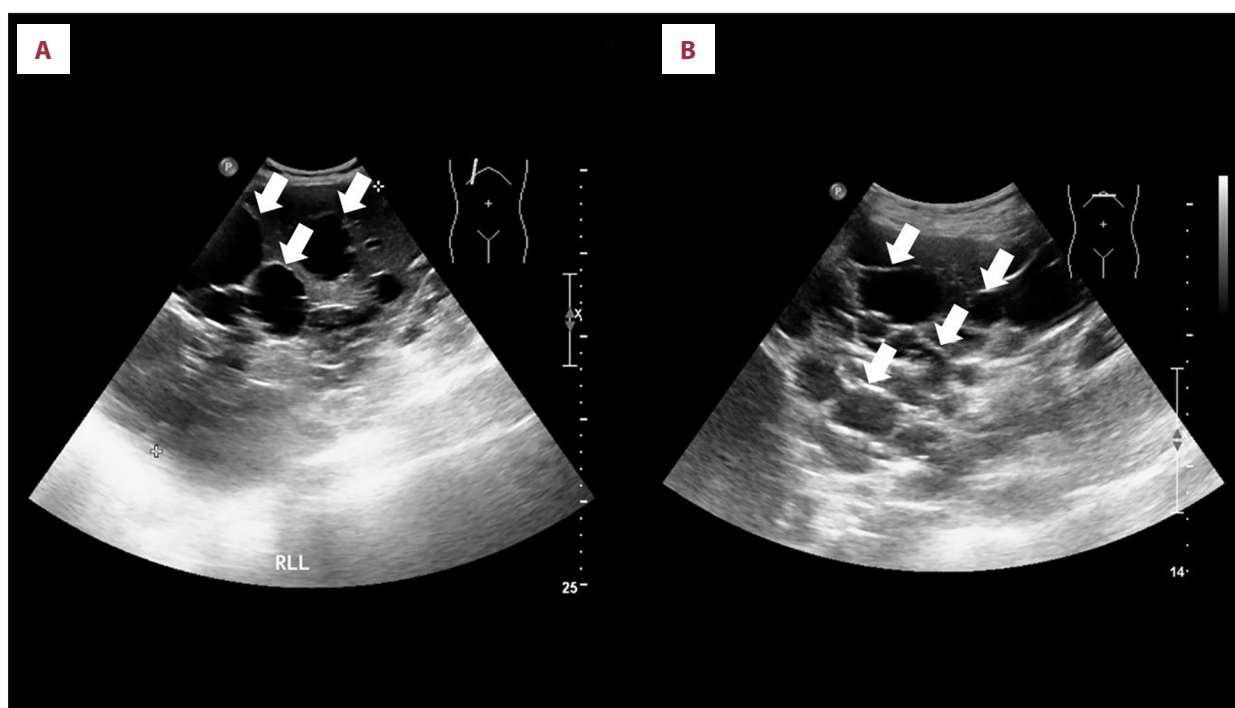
Abdominal ultrasonography. Ultrasound images demonstrate numerous anechoic ovoid lesions (arrows) occupying the majority of the right (A) and left (B) hepatic lobes, consistent with multiple hepatic cysts.
